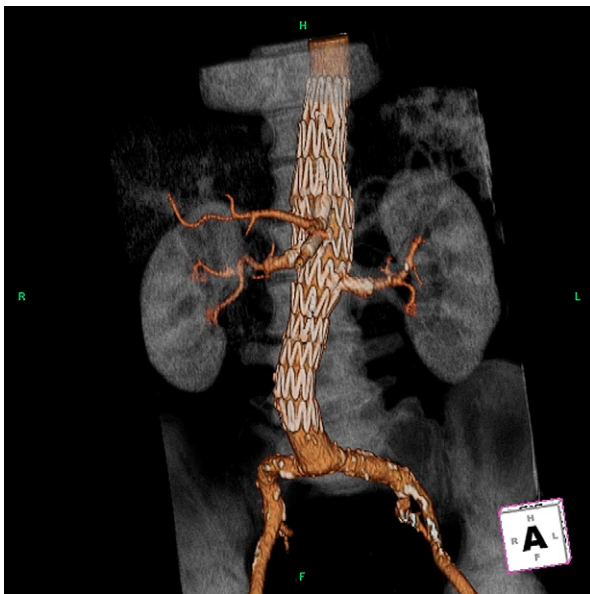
3D-VR reconstruction of the post-procedure CT scan of a device with four reinforced fenestrations. This design was used to treat a type III thoracoabdominal aneurysm developed after previous type IV TAAA open tubular repair. The aortic lumen was narrow at the level of the visceral arteries allowing the use of four reinforced fenestrations mated with Advanta stent grafts (Atrium Medical Corporation, Hudson, NH, USA).
